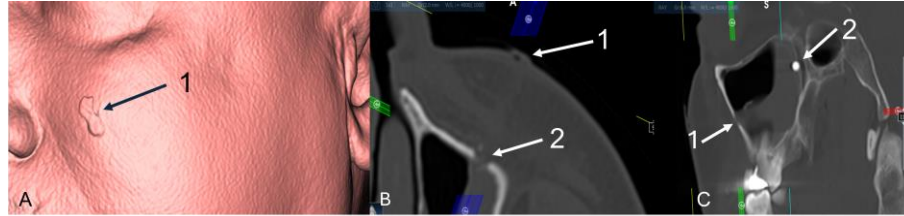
Visualization of the entry wound based on CT scan. A. 3D visualization of external soft tissues of the left cheek. 1: entry point at the skin. B. Axial view. Trajectory of the bullet. 1: entry point at the skin. 2: entry point at the anterior wall of the left maxillary sinus. C. Sagittal view. 1: entry point at the anterior wall of the left maxillary sinus. 2: position of the bullet in the posterior wall of the left maxillary sinus.
